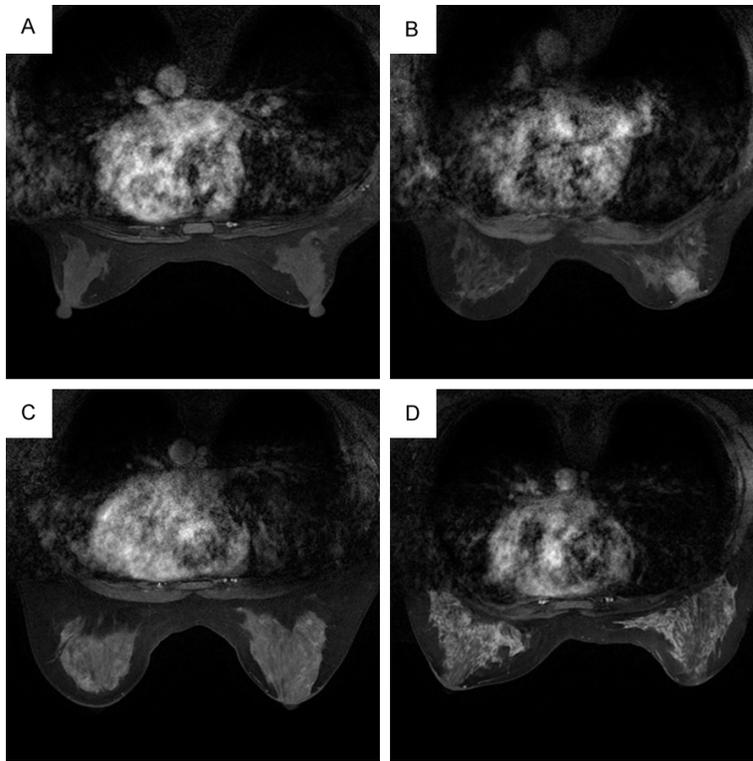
Representative images of varying amounts of background parenchymal enhancement (BPE), as qualitatively assessed. Post-contrast, fat-saturated T1-weighted images at the first dynamic phase showing minimal (A, left), mild (B, left), moderate (C, right), and marked (D, left) BPE in the contralateral breast.
